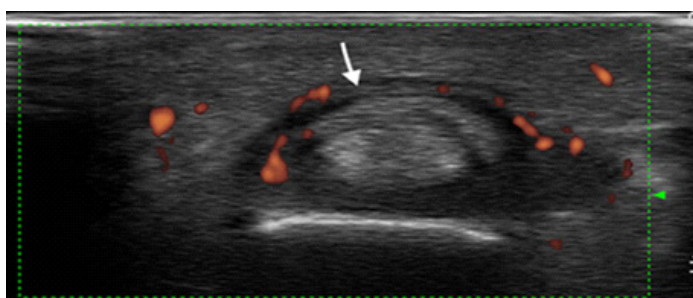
Power Doppler Technology - A2 pulley.
